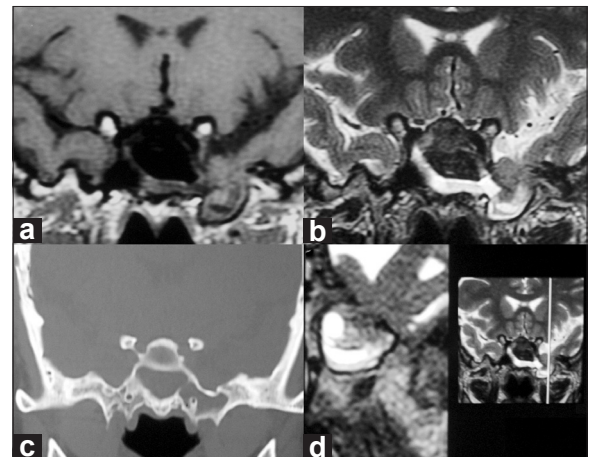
(a, b and d) Coronal MR images showing the temporal lobe encephalocele; (c) CT scan showing the lateral recess of the sphenoid sinus
